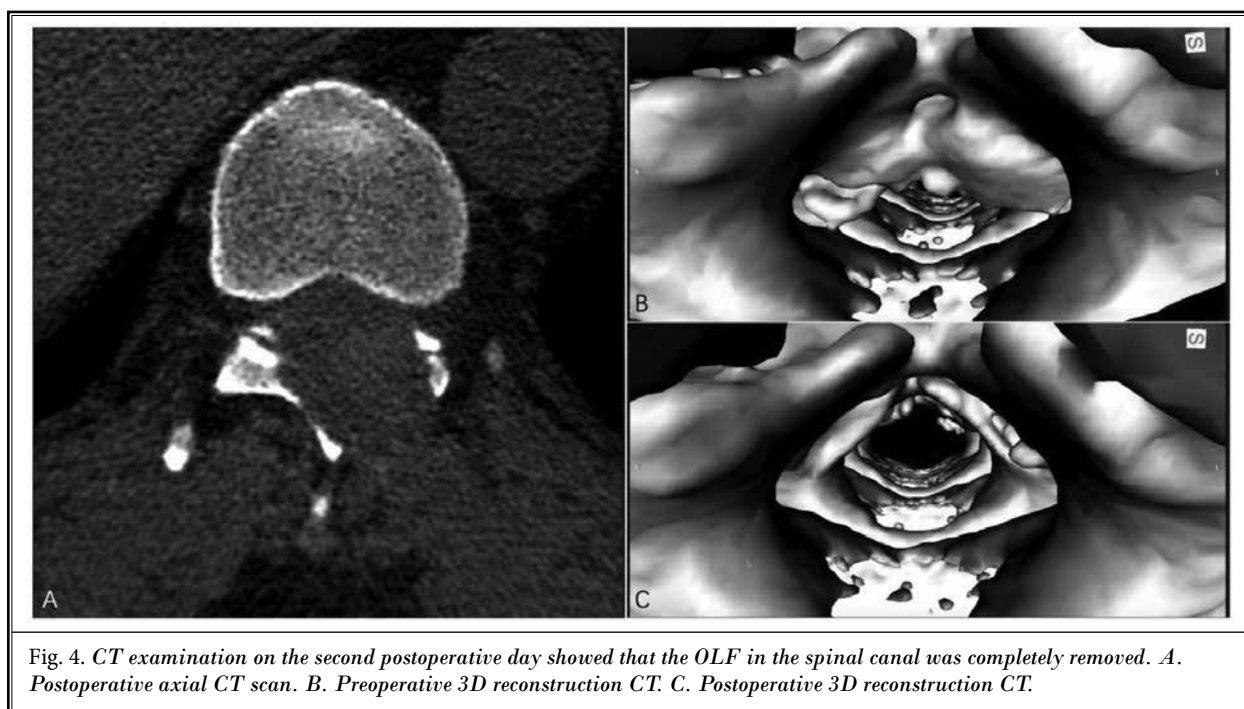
CT examination on the second postoperative day showed that the OLF in the spinal canal was completely removed. A. Postoperative axial CT scan. B. Preoperative 3D reconstruction CT. C. Postoperative 3D reconstruction CT.
